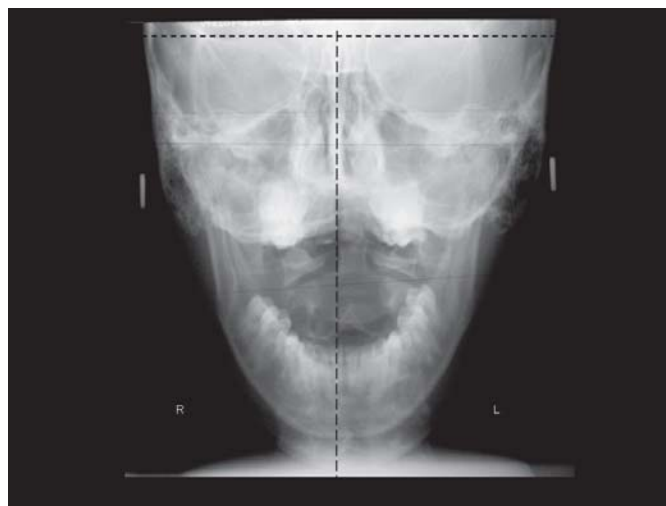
Postero-anterior (p-a) skull radiograph showing vertical and horizontal reference planes used to compare width of right half of cranium with left half.
